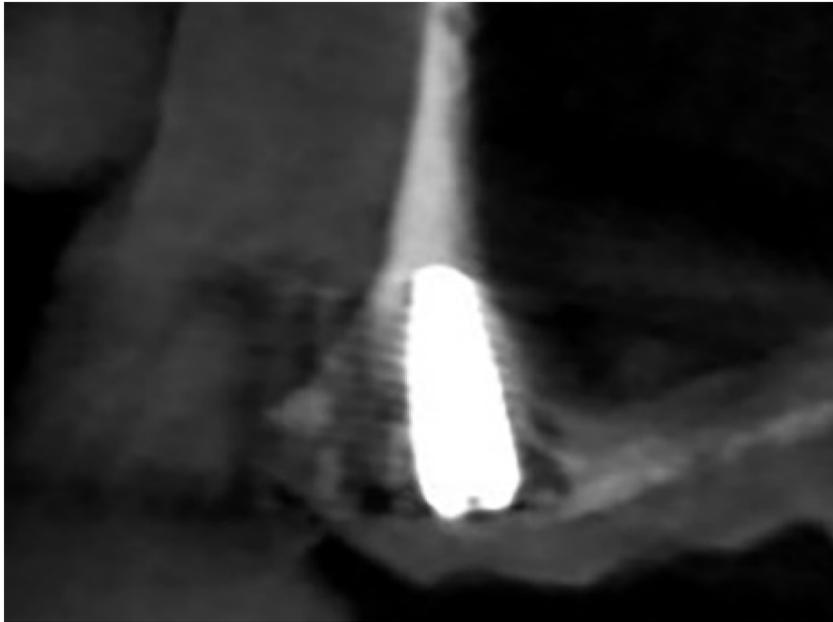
Postoperative CBCT of the tilted implant.
